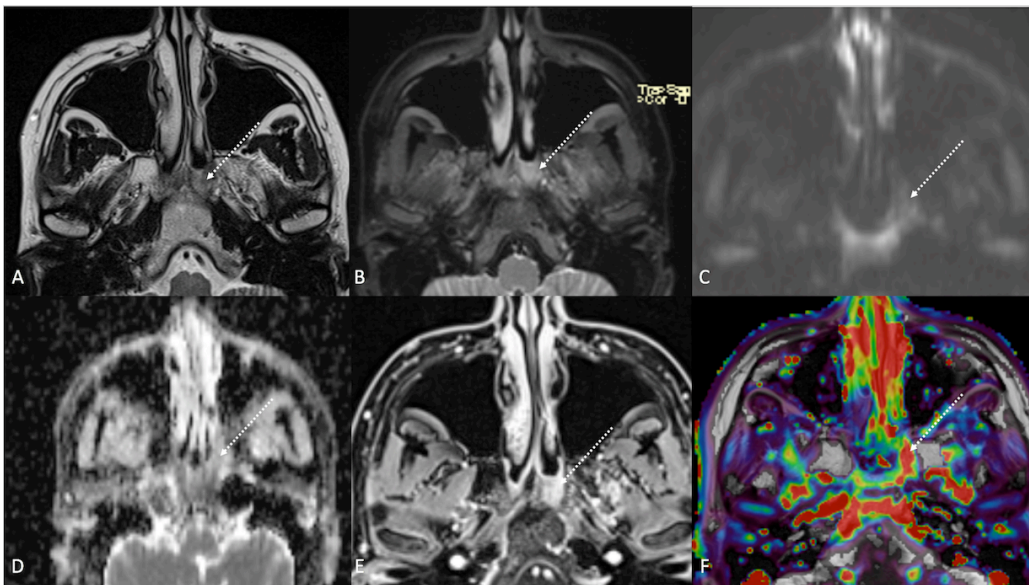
Pre-treatment Magnetic Resonance Imaging (MRI) of a 75-year-old male patient with Human Papilloma Virus positive carcinoma of the left palatine tonsil (T2N0; white arrows). MR images show a bulky tumour arising from the left palatine tonsil that extends into the ipsilateral amigdaloglossus sulcus. The lesion shows hyperintense signal on T2-weighted (a), T2-weighted fat saturated (b), and diffusion weighted  $b_{800}$  images (c) compared to muscle signal, very low median apparent diffusion coefficient value ( $0.642 \times 10^{-3} \text{ mm}^2/\text{s}$ ) (d), vivid and homogeneous enhancement on T1-weighted image after gadolinium contrast agent injection (e), and high  $K(\text{trans})$  value ( $375,88 \times 10^{-3} \text{ min}$ ) on dynamic contrast enhancement-perfusion weighted imaging (f).
